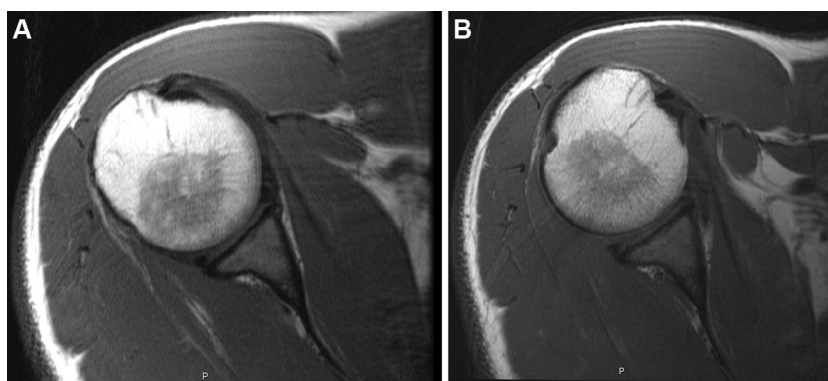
(A) Magnetic resonance imaging of shoulder immobilized in neutral rotation sling. (B) Magnetic resonance imaging of shoulder immobilized in internal rotation sling.
